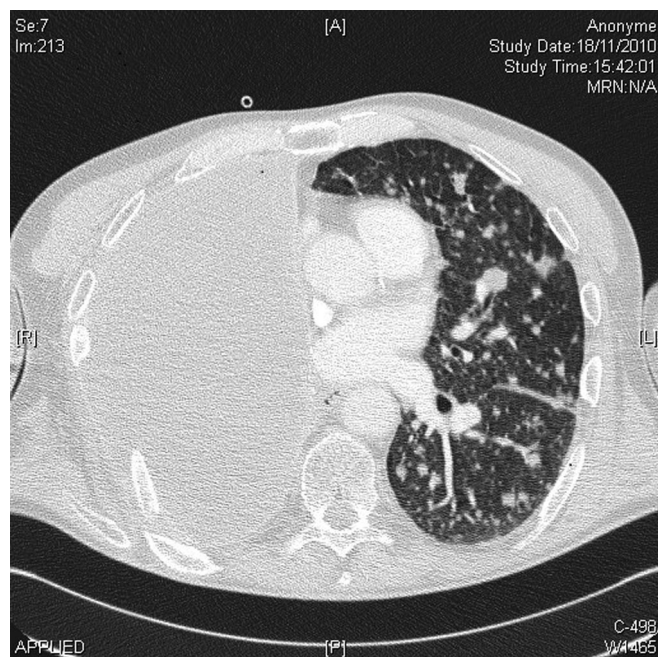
Case 1: Computed tomography of the chest showing diffuse parenchymal nodularity on the remaining lung, lymphangitis, and pleural effusion.
